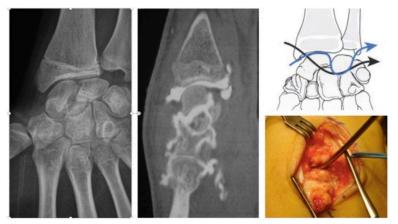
Propagation of the forces throughout the carpal bones explaining the different associations of lesions. The forces drawn in black are associated with osseous lesions of the scaphoid, capitate, lunate, hamate, and triquetrum. The forces drawn in blue are associated with ligamentous lesions of the scaphoradial, scapholunate, lunocapitate, and lunotriquetral ligaments. Patient presenting an old Fenton lesion with rotational dislocation of the head of the capitate which is well visualized on a CT-arthrogram. Perioperative view of a fracture of the capitate.
